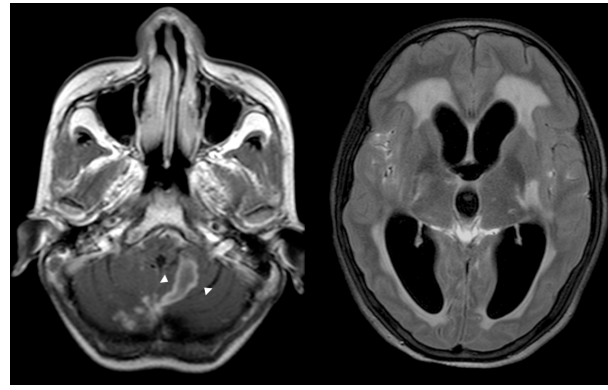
MRI Brain T1w post-contrast (left panel) and T2-FLAIR (right panel) shows ring and disc enhancing lesions in the cerebellar vermis measuring 2.8 cm (white arrowhead), and severe hydrocephalus with periventricular oozes.
